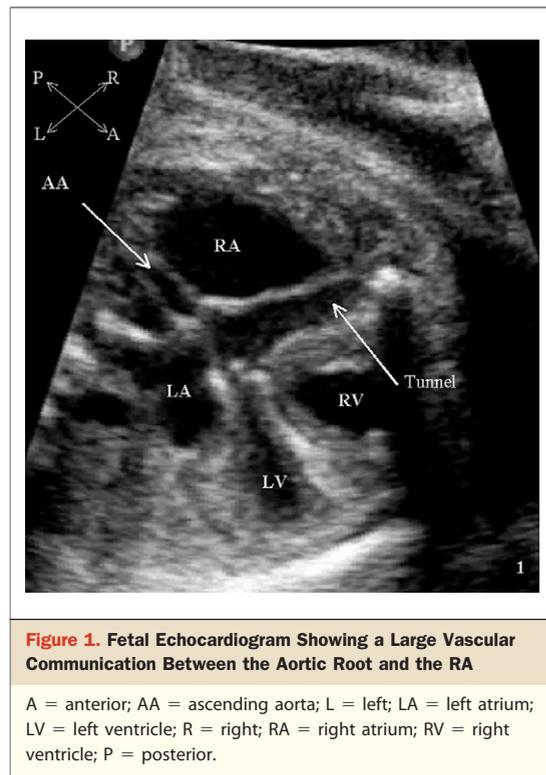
Fetal Echocardiogram Showing a Large Vascular Communication Between the Aortic Root and the RA
